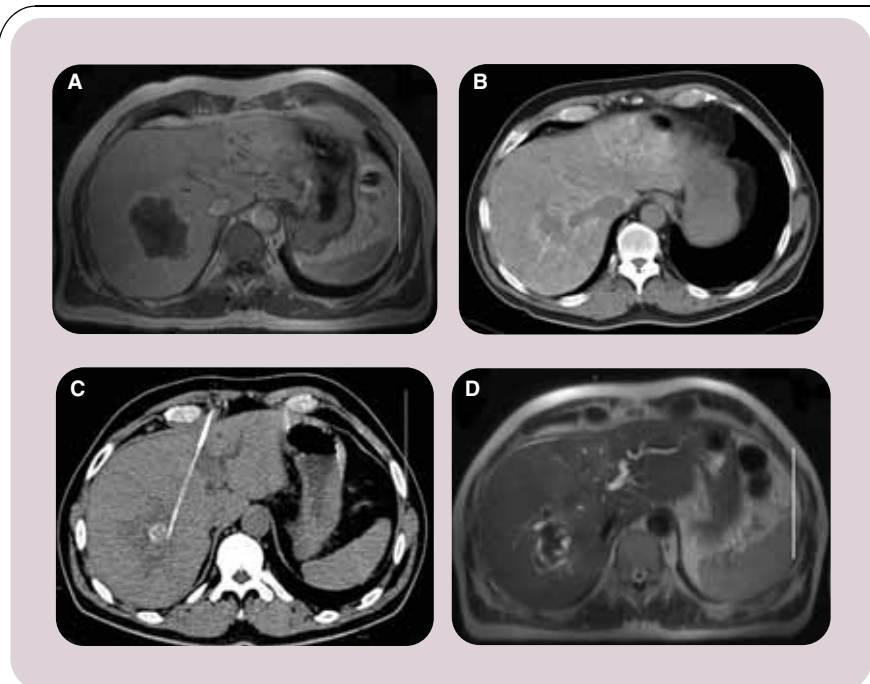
Downsizing of colorectal liver metastases using transarterial chemoembolization (TACE) followed by laser-induced thermotherapy (LITT). (A) Postcontrast T1WI showing a large right hepatic lobe metastatic mass in a patient with colorectal carcinoma that was not treatable by LITT. (B) The same lesion after three TACE sessions showing lipiodol retention and size reduction. (C) First LITT session to ablate the lesion. (D) Follow-up T2W magnetic resonance image after LITT, showing a necrotic lesion with no evidence of recurrence.
